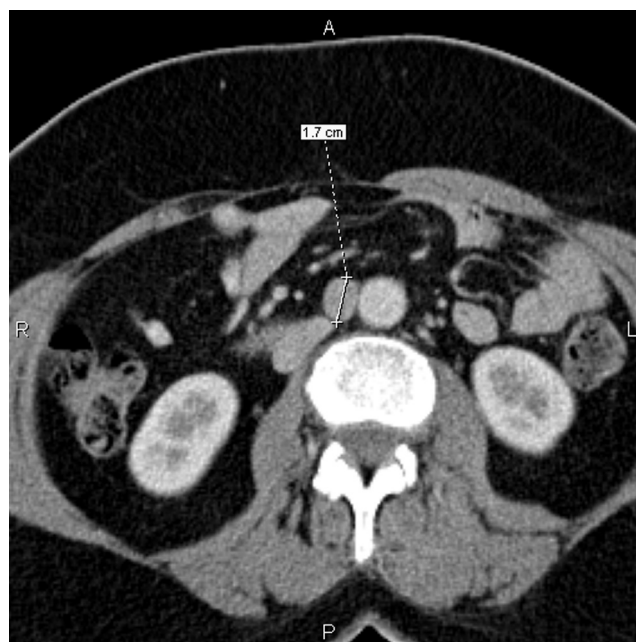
Enlarged paraaortic lymph node at computed tomography scan.
